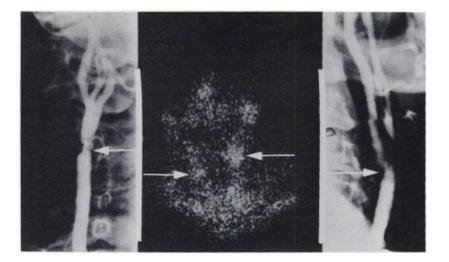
Comparison of bilateral carotid angiograms with a 2-day scintigram from Subject 2. Thyroid gland is visible at bottom of scintigram, and the blood pool in cerebral venous sinuses at top. The isolated right common carotid lesion (left side of scintigram) sequesters I-125-LDL, while extensive disease of left common and internal carotids, which extends much higher in the neck, accumulates far more radio-labeled lipoprotein (right side of scintigram).
